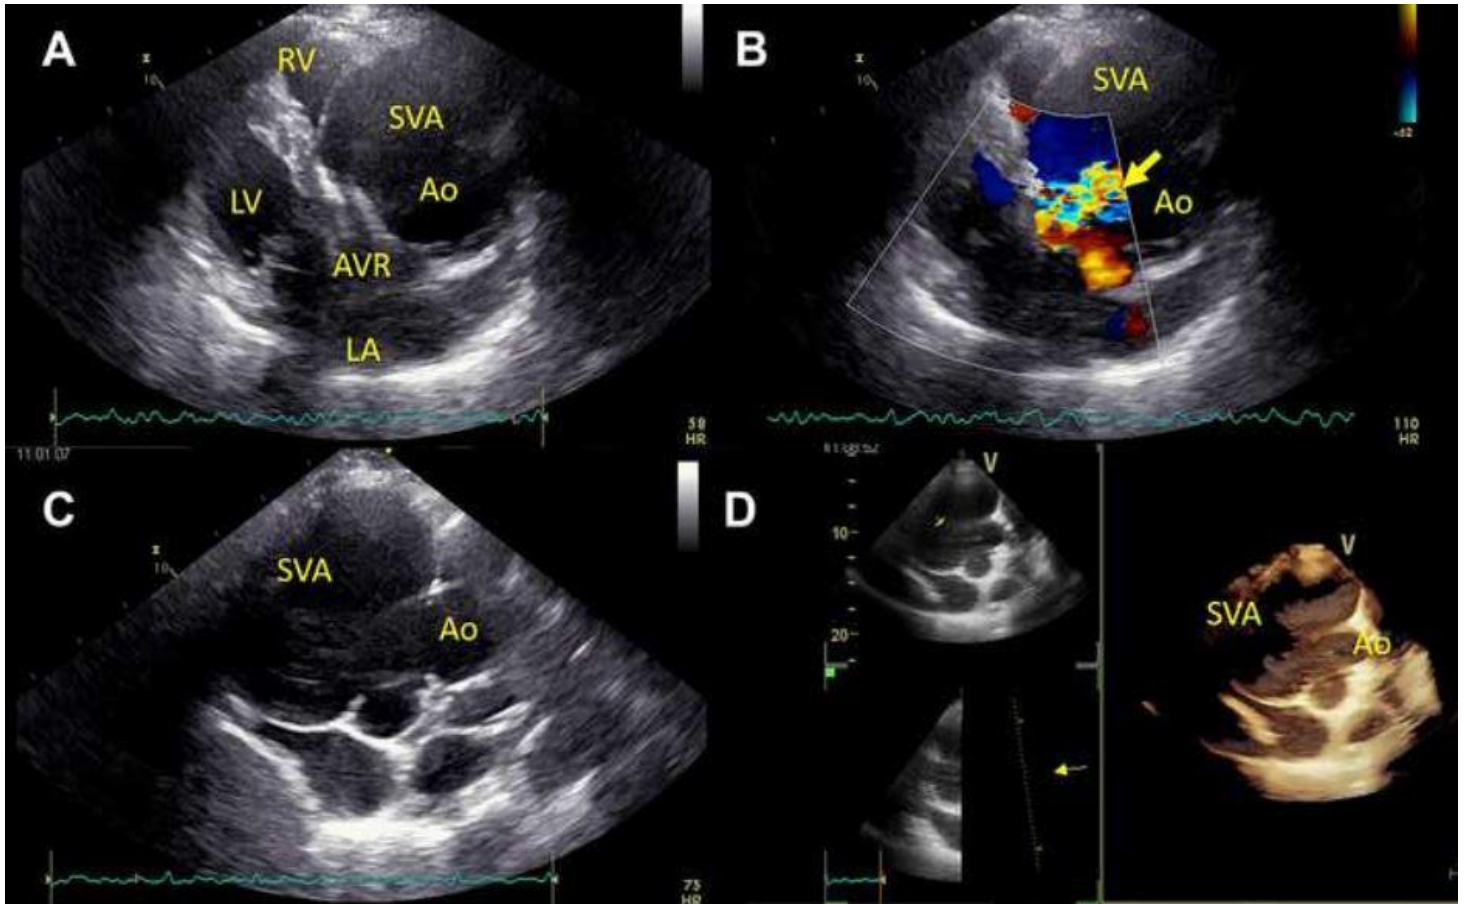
Echocardiographic images of the patient. A. Transthoracic echocardiography demonstrating SVA on parasternal long axis, B. Color Doppler imaging demonstrating outflow from AVR and relation with SVA on parasternal long axis, C. Image demonstrating SVA on parasternal short axis, D. Real-time 3D-transthoracic echocardiography demonstrating SVA. Ao, Aorta; LA, left atrium; LV, left ventricle; RV, right ventricle; SVA, sinus of Valsalva aneurysm.
